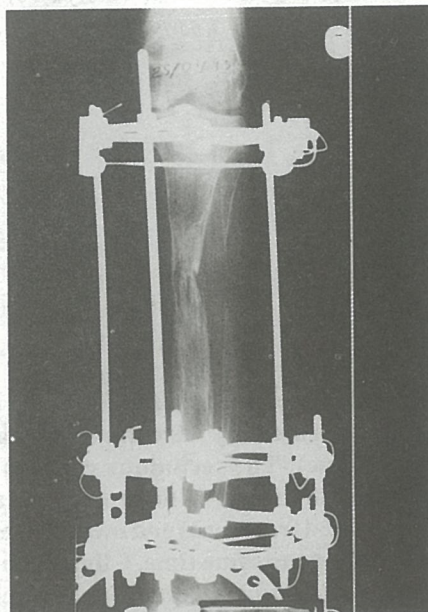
The radiograph of the congenital pseudarthrosis of the tibia after application of a ring external fixator with compression technique at the pseudarthrosis site and lengthening at the proximal tibia.
